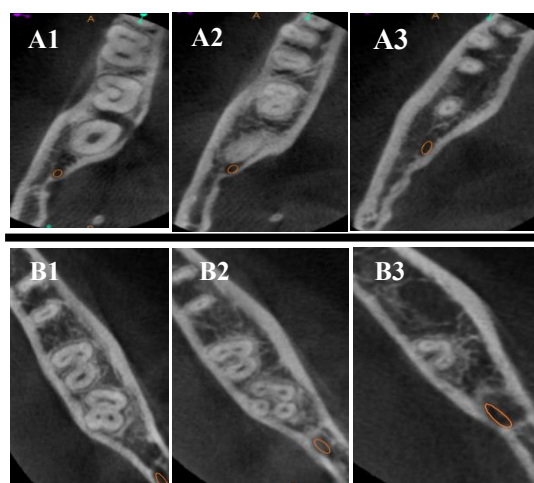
CBCT images showing the C-shaped canal configuration: (A) changes or (B) no changes. (A1 and B1), coronal third; (A2 and B2), middle third; (A3 and B3), apical third.
